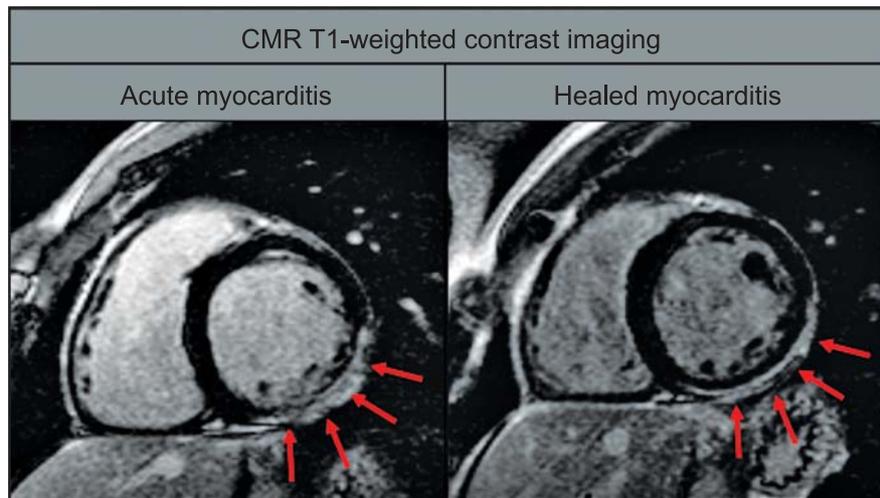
T1-weighted short-axis gradient-echo images in a patient with biopsy-proven myocarditis, demonstrating subepicardial late gadolinium enhancement (LGE, red arrows) in the inferolateral segments during acute presentation (left) indicative of myocardial damage. At follow up after three months a shrinkage in the extent of LGE was observed (right).
